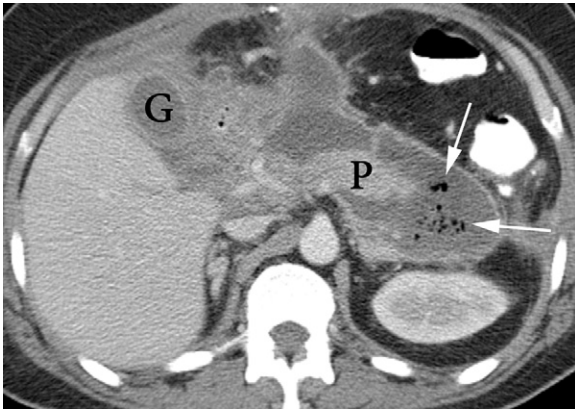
Acute necrotizing pancreatitis. On contrast-enhanced computed tomography scan, the pancreas (P) is surrounded by peripancreatic inflammation that contains bubbles of air (arrows) due to sterile necrosis. G, Gallbladder. (From Feldman M, Friedman LS, Brandt LJ: *Sleisenger and Fordtran's Gastrointestinal and Liver Disease*, 8th ed. Philadelphia, Saunders, 2006.)
